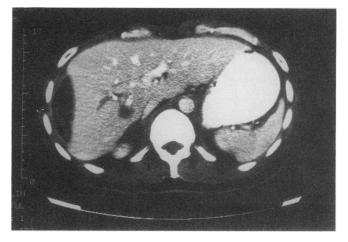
CT scan 1 mo later showed significant improvement of the hepatic laceration and the parenchymal hematoma.
